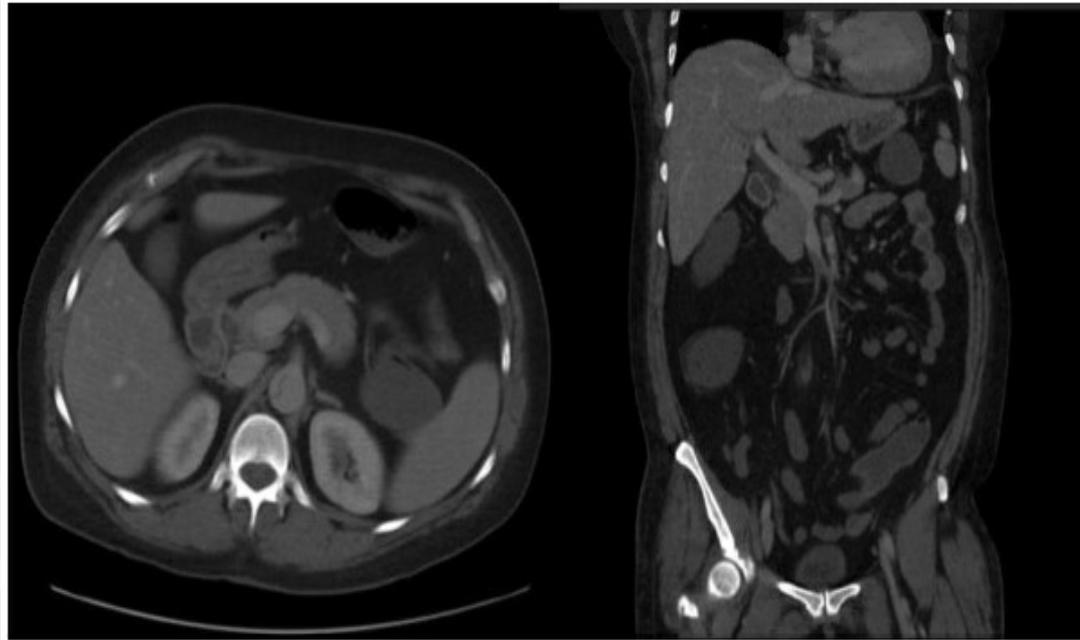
Computed tomography angiography (CTA) imaging of both dynamic and static obstruction of the superior mesenteric artery (SMA).
